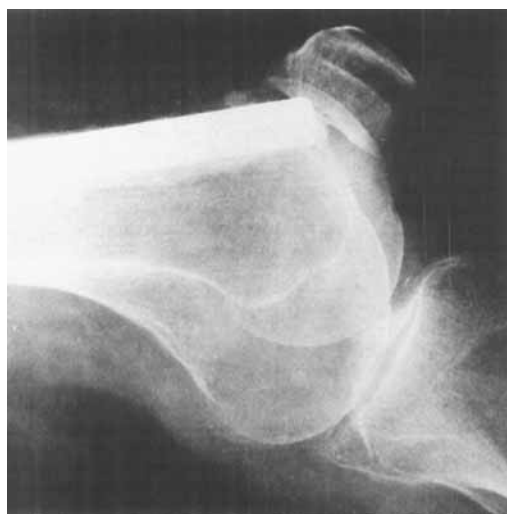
Lateral radiograph of the knee 1 week after operation. There is acrylic cement in the knee joint and penetration of the stem of the prosthesis with its tip lying against the articular surface of the patella.
